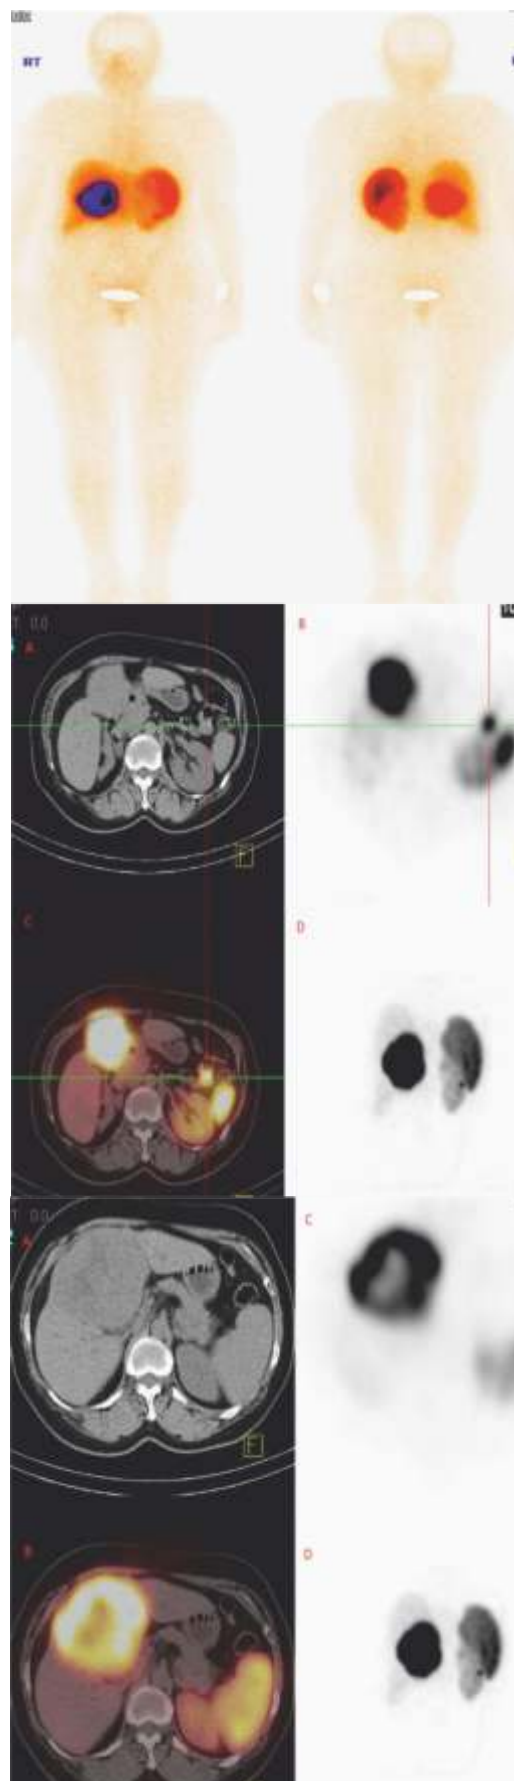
Whole body  $^{99m}\text{Tc}$ -HYNICTOC scintigraphy showing intense uptake in the liver lesion and tiny foci of uptake noted close to left kidney.
